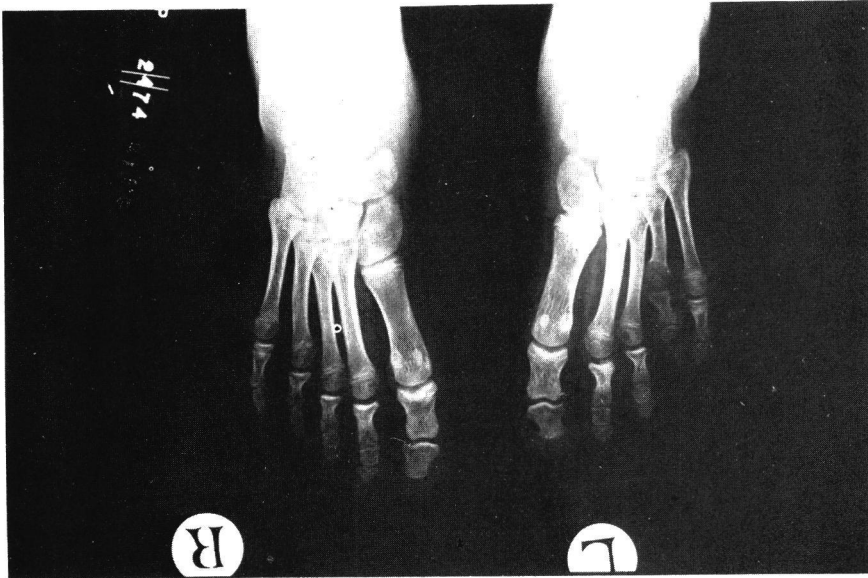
Radiograph Showing Shortening of Left 4th Metatarsal.
